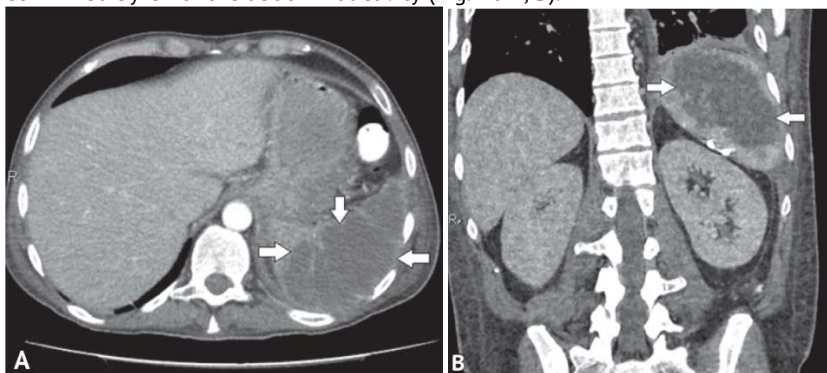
Computed tomography of the abdomen with contrast enhancement. A - axial projection; B - front view. The formation of extensive areas of liquid density in the spleen (arrows)
